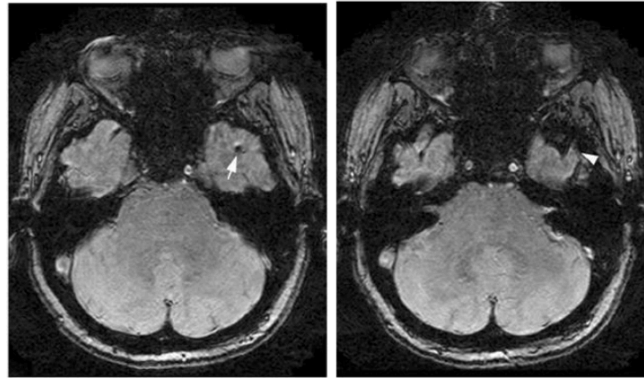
Axial T2-weighted MRI; left shows potential CMB (arrow), right identifies it as bone artifact (arrowhead).
